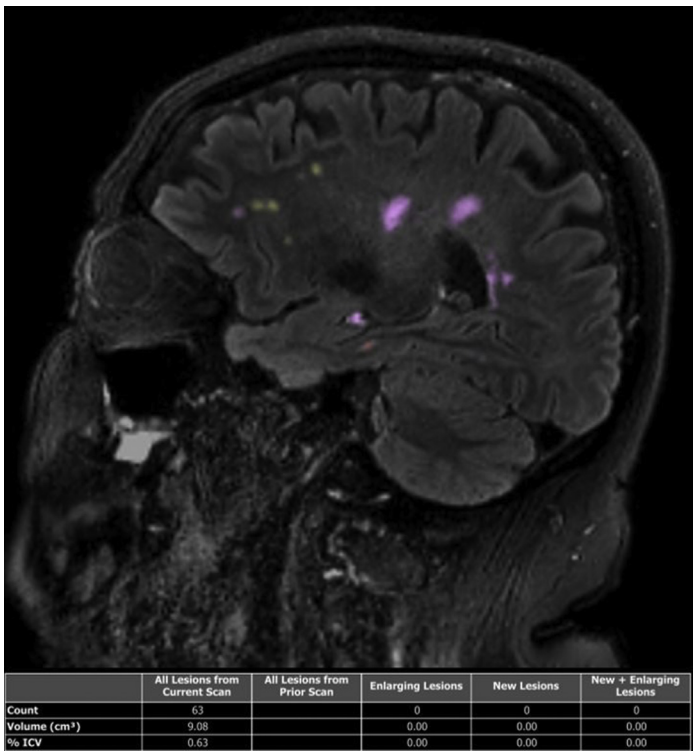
The automated lesion quantification in multiple sclerosis provides a colored segmentation map of FLAIR hyperintensities and assigns color based on the lesion location. In the report, the lesion distribution and overall lesion volume are shown. On follow-up examinations the difference is also provided, simplifying interpretation and reducing reading time.
